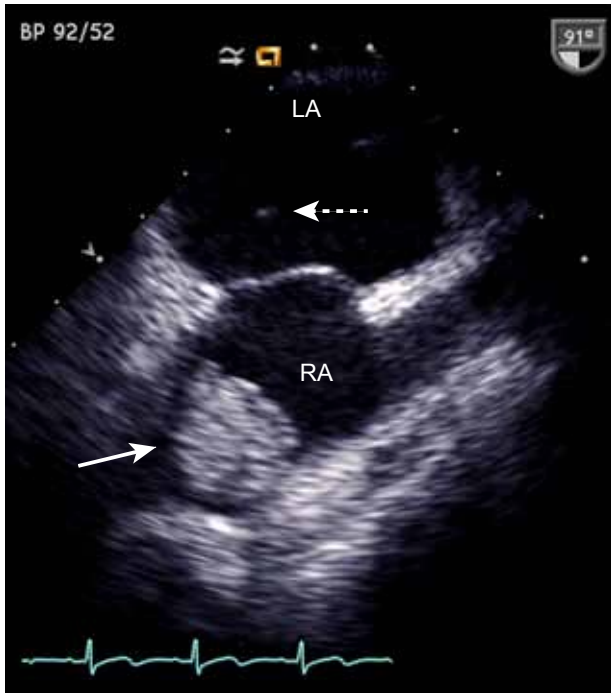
Transesophageal bicaval view demonstrating right atrial mass (RA, solid arrow) and left atrial mass (LA, dashed arrow).
